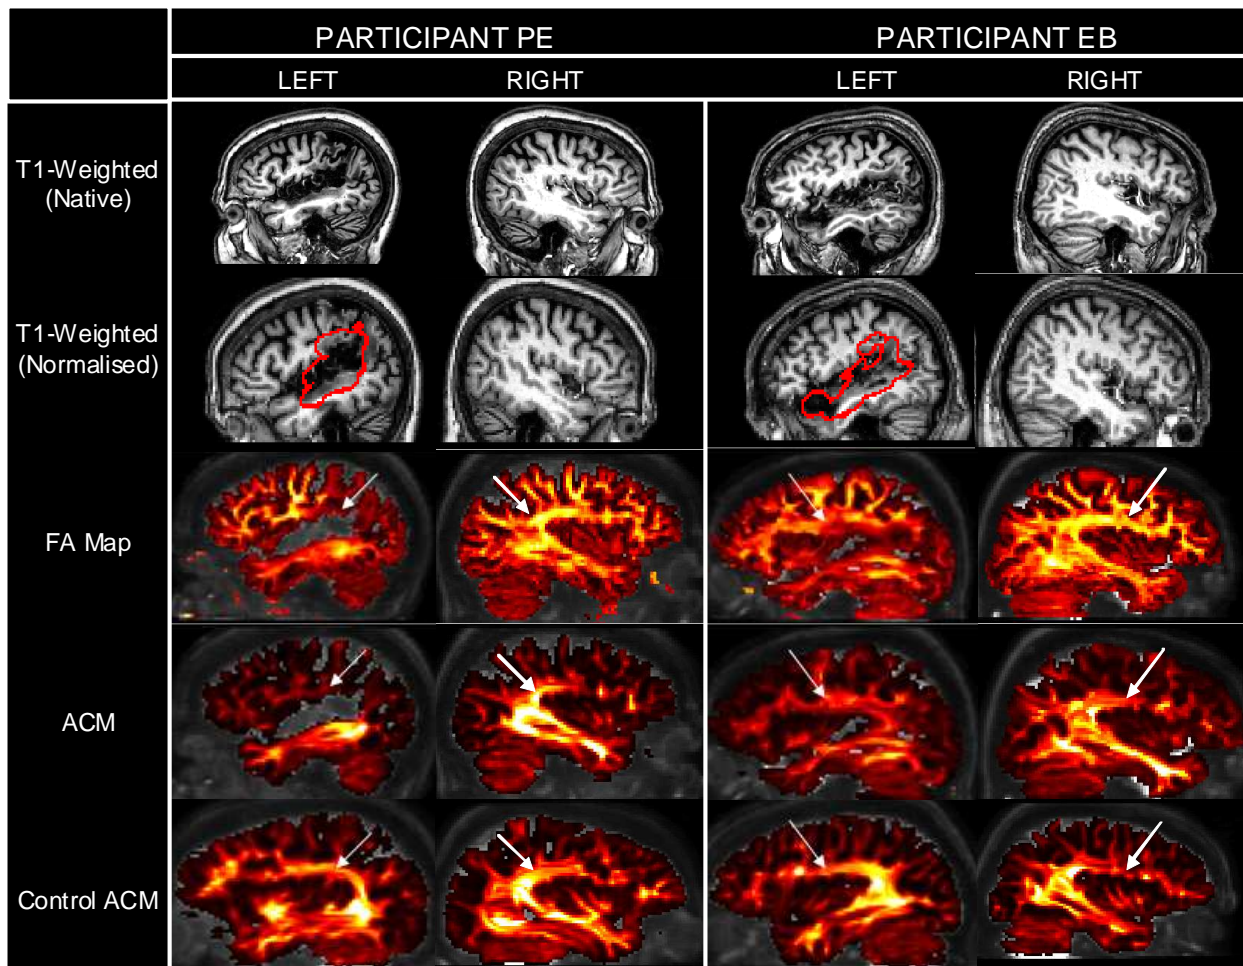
Imaging results for posterior cases PE (left) and EB (right). T1-weighted scan (top row); normalised T1-weighted scan with lesion outline shown in red (second row); FA map (third row); ACM (fourth row); ACM from matched healthy control participant (bottom row). Healthy control participant for PE = female, 72 years old, 16 years of education. Healthy control participant for EB = male, 63 years old, 17 years of education. All images are shown in native space apart from the normalised T1-weighted images. Arrows indicate features of interest referred to in text on FA and ACM images.
